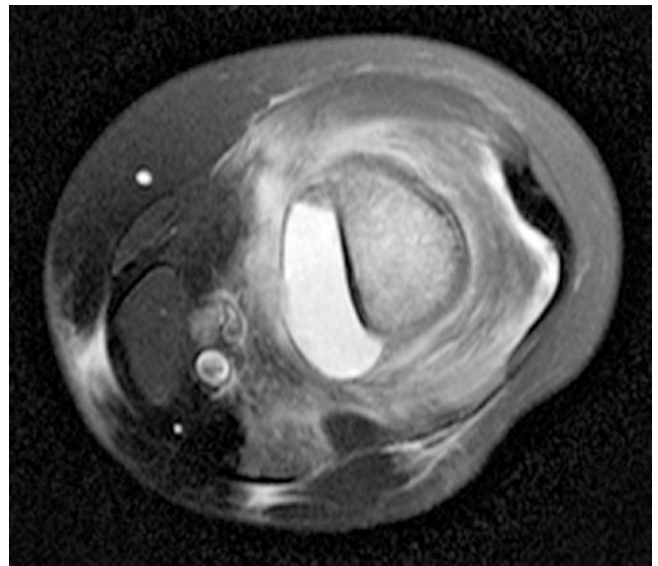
Subperiosteal abscess formation on axial MRI surrounding soft tissue high signal
